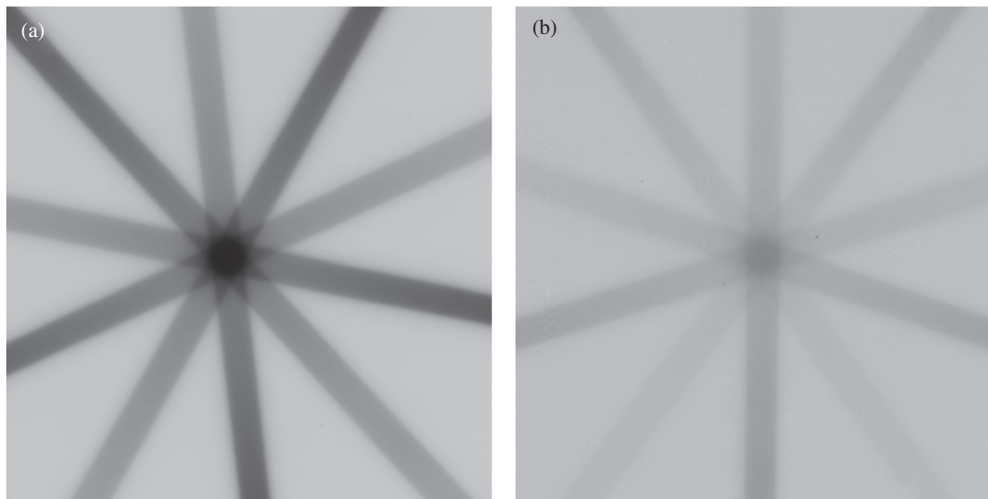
A star shot film acquired with (a) the Kodak EDR2 radiographic film, after development and digitization or (b) the ISP EBT2 radiochromic film. Both are exposed to 200 MU per beam.
